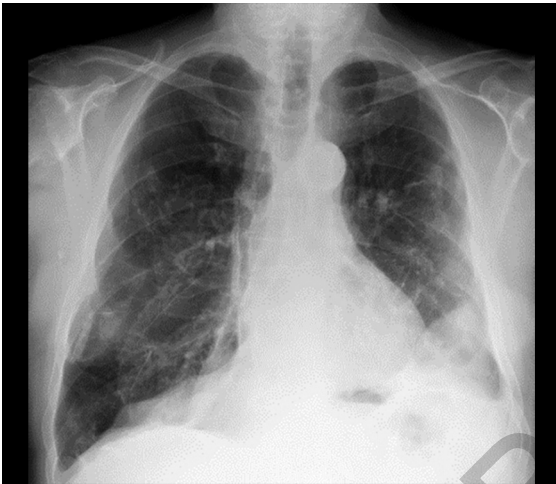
X-ray findings—shift of the fissure lines and hilar structures toward the affected area and overall loss of volume with elevation of the hemidiaphragm.
